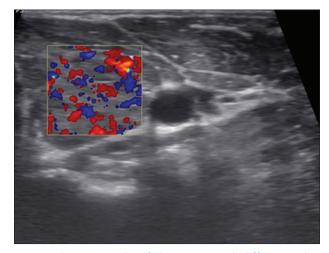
Ultrasonography of the patient with diffuse uptake in Figure 2 – showing enlargement and increased vascularity of both lobes – suggestive of thyroiditis
